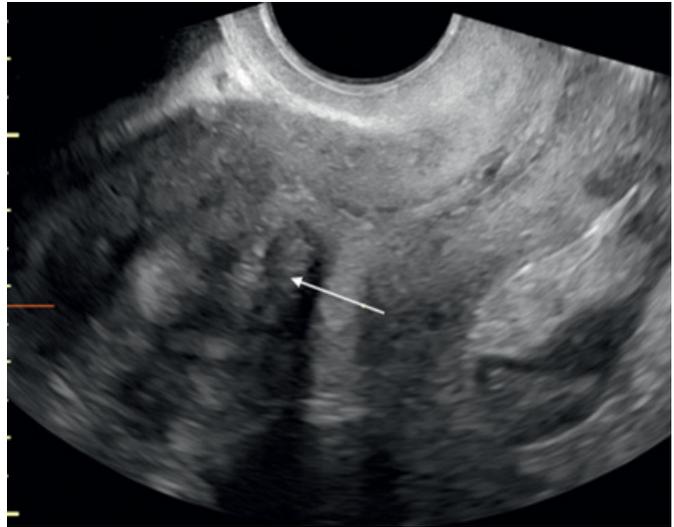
Transvaginal ultrasound of FIGO I myoma, white arrow indicating fibroid.
